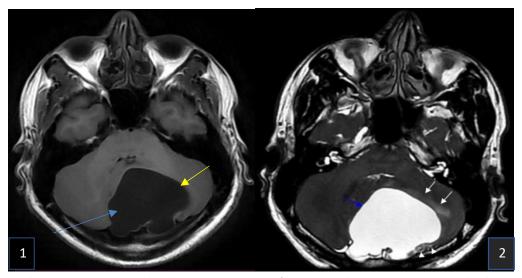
Axial non-contrast T1-weighted image
